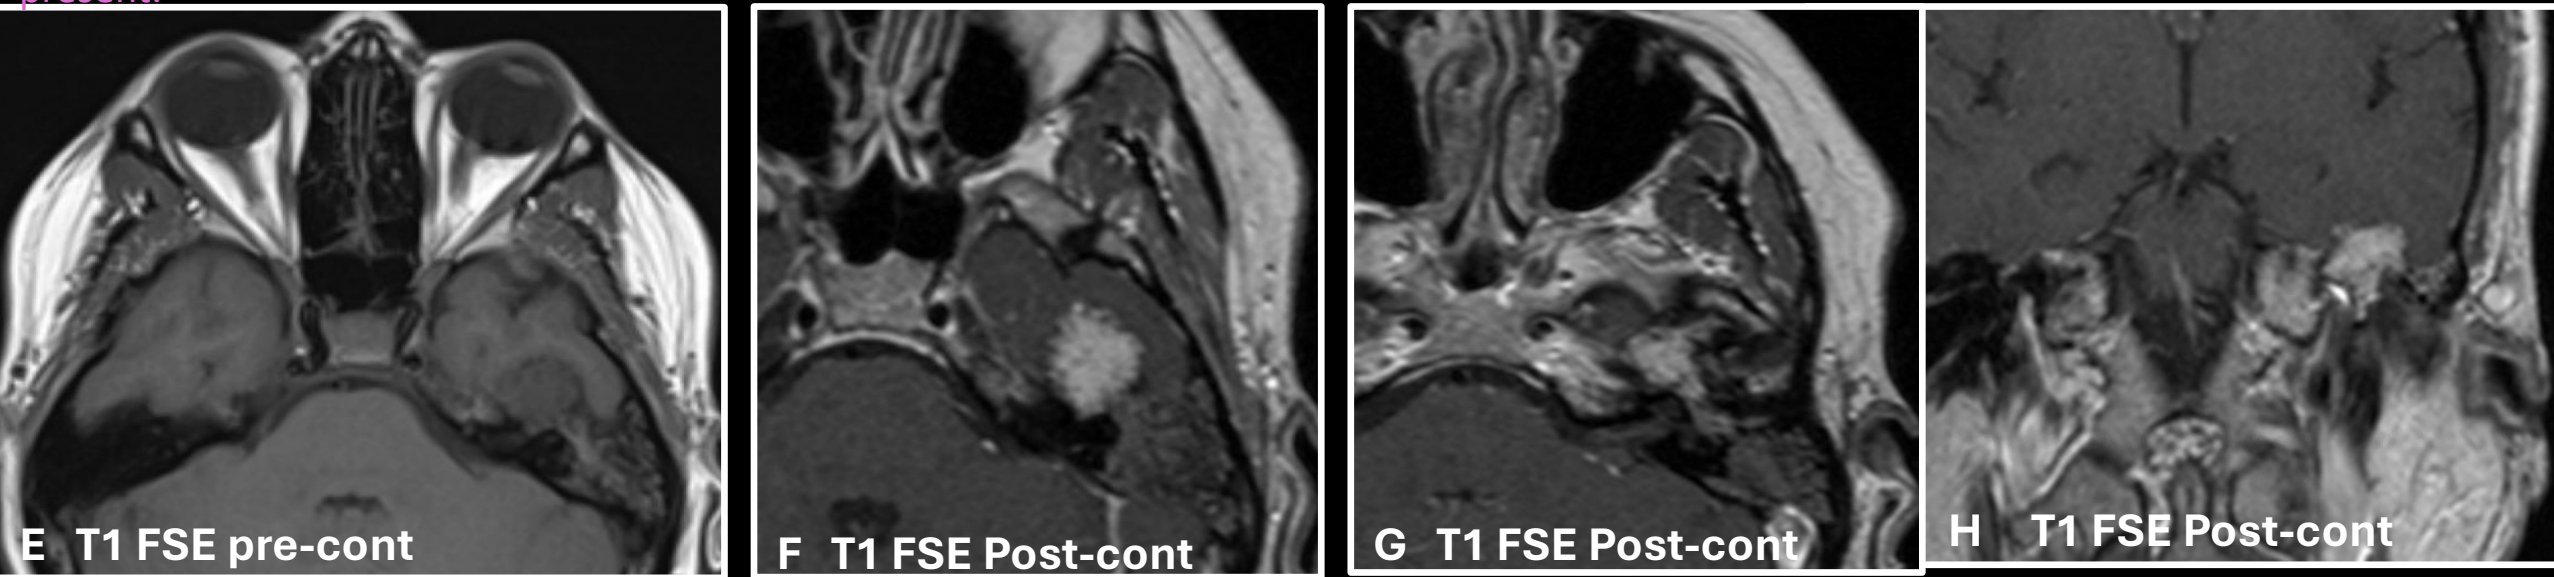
Axial MRI images (A-G) and coronal (H) demonstrate a T2 hyperintense, T1 hypointense, non-restricting, and hyper-enhancing extra-axial mass along the greater wing of the left sphenoid causing mass effect on the left temporal lobe anteriorly and superiorly, with no significant parenchymal edema. The lesions extends from the geniculate segment of the left facial nerve, with thickening of the facial nerve and surrounding hyper-enhancement. Post-obstructive mucosal thickening and enhancement are noted in the left mastoid air cells, with fluid signal present.
